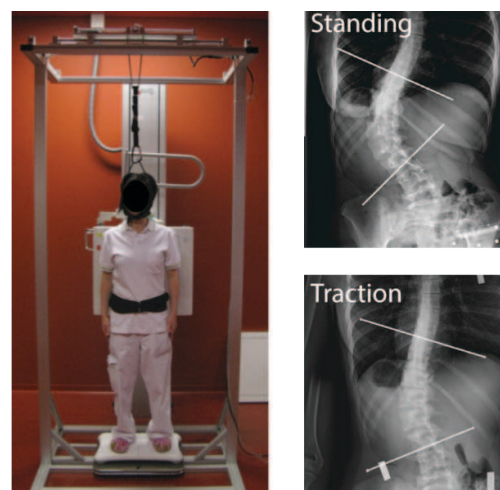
The spinal suspension test has been designed to ensure an axial loading of the patients' spine. A platform allows rotating the patient to acquire orthogonal radiographic images before and after elevation with a force equivalent to 30% of the patient's weight. The radiographs before and after traction enabled to quantify the correction of the curve induced by the test and are used to assess the spinal stiffness.
